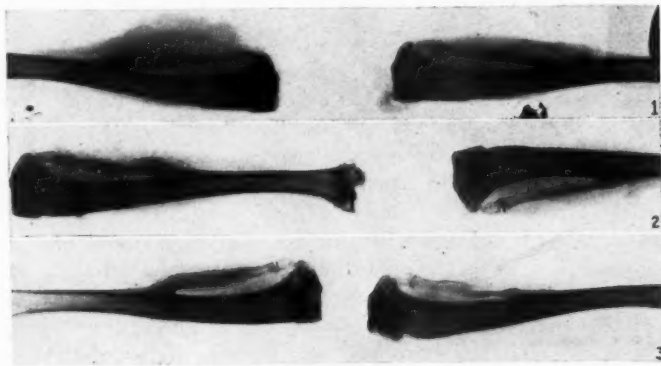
X-ray three weeks after removal of fibula and replacement with ground bone paste (left) and bone chips or segments (right).
